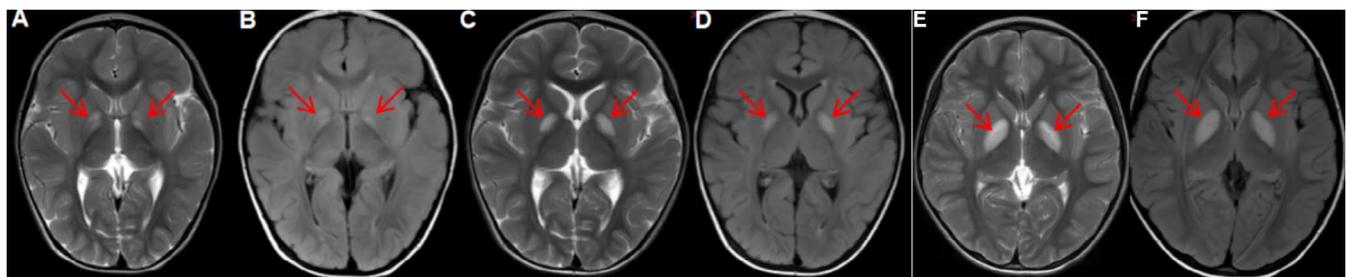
Brain MRI images. Brain MRI of Proband 1 at 14 months old, showing bilateral symmetrical T2 and FLAIR hyperintensities in the basal ganglia (A, B) (red arrow). Brain MRI of Proband 1 at 15 months old, showing bilateral symmetrical T2 and FLAIR hyperintensities in the basal ganglia, with a slightly expanded area compared to the previous scan (C, D) (red arrow). Brain MRI of Proband 2 at 5.5 years old, showing bilateral symmetrical T2 and FLAIR hyperintensities in the globus pallidus (E, F) (red arrow).
